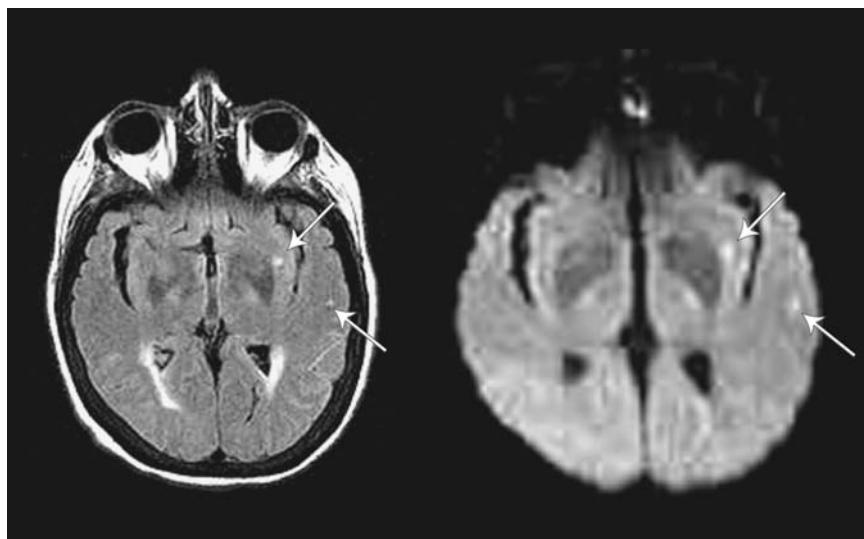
Nonspecific white matter changes versus acute ischemic infarction. Sixty-one-year-old female with hypertension. FLAIR-weighted images demonstrate multiple hyperintense white matter foci of unclear chronicity. DWIs demonstrate that lesions in the left external capsule and left temporal subcortical white matter (arrows) are acute. Abbreviations: DWI, Diffusion-weighted image; FLAIR, fluid-attenuated inversion recovery.
